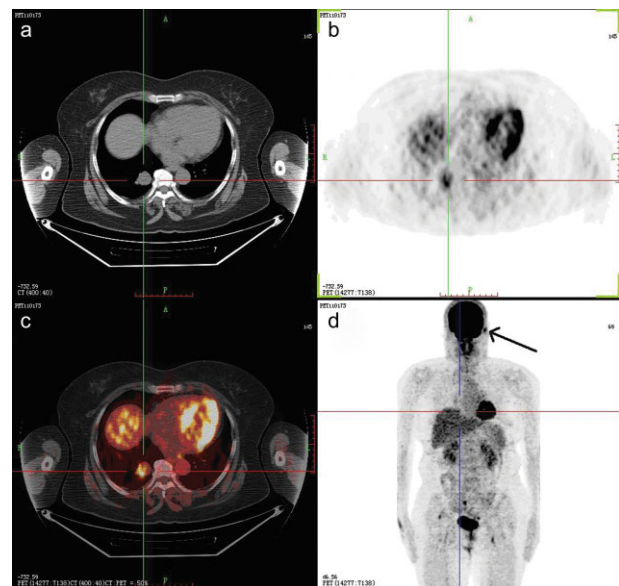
Chest positron emission tomography-computed tomography (PET-CT) scan. (a) axial view, CT in mediastinal window; (b) PET images; (c) fused PET/CT; (d) anterior maximum intensity projection PET images showing a small high-metabolism lesion found in the left external auditory canal.
